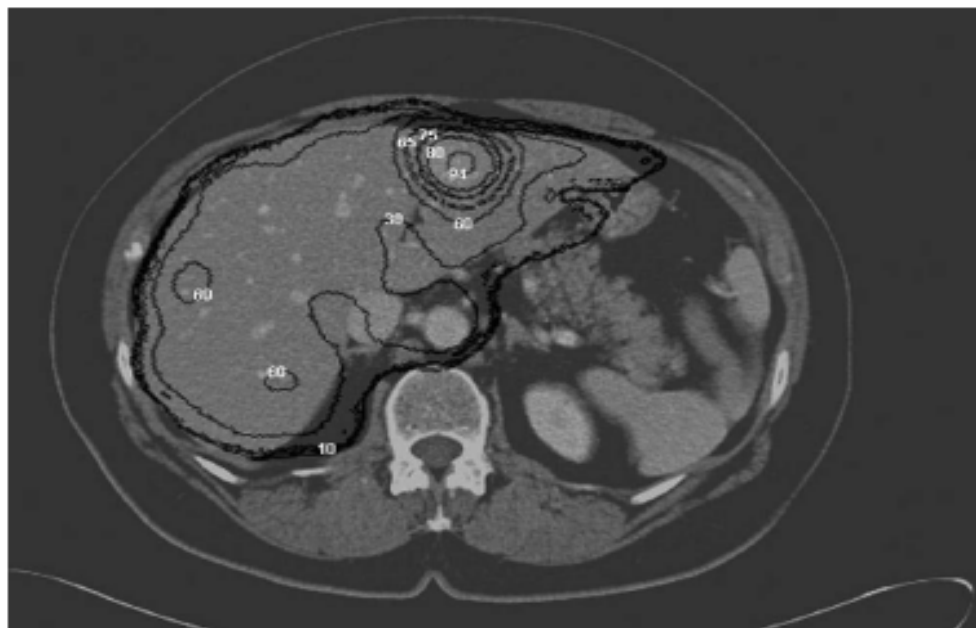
Calculated dose distribution after administration of ^{131}I -MIBG superimposed on axial CT scan.
